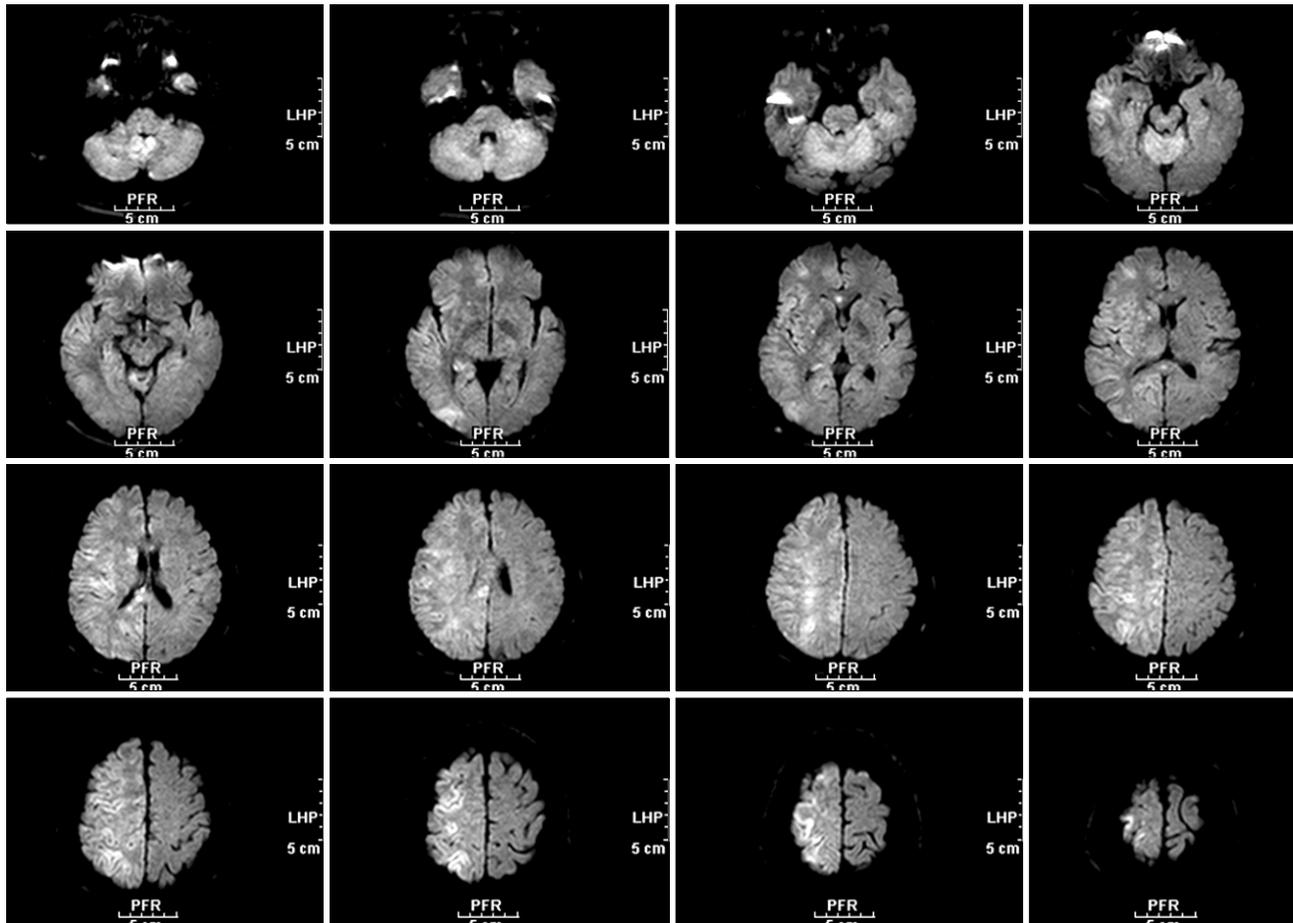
Brain MRI diffusion-weighted image revealed the acute cerebral infarction in the entire right hemisphere.
